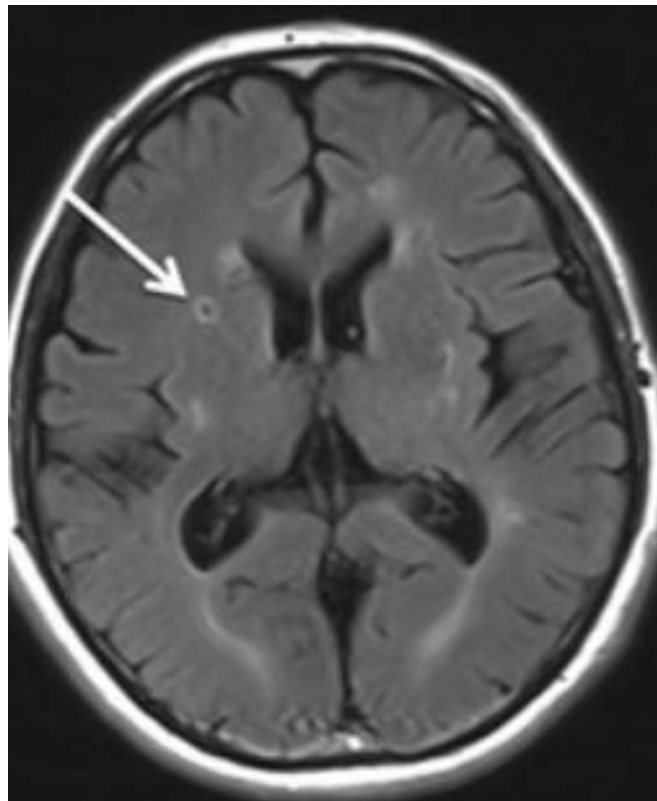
MRI- defined lacunar infarct with ring of hyperintensity and core of hyperintensity (white arrow). Reference form Norrving B. Pract Neurol. 2008 Aug;8(4).
